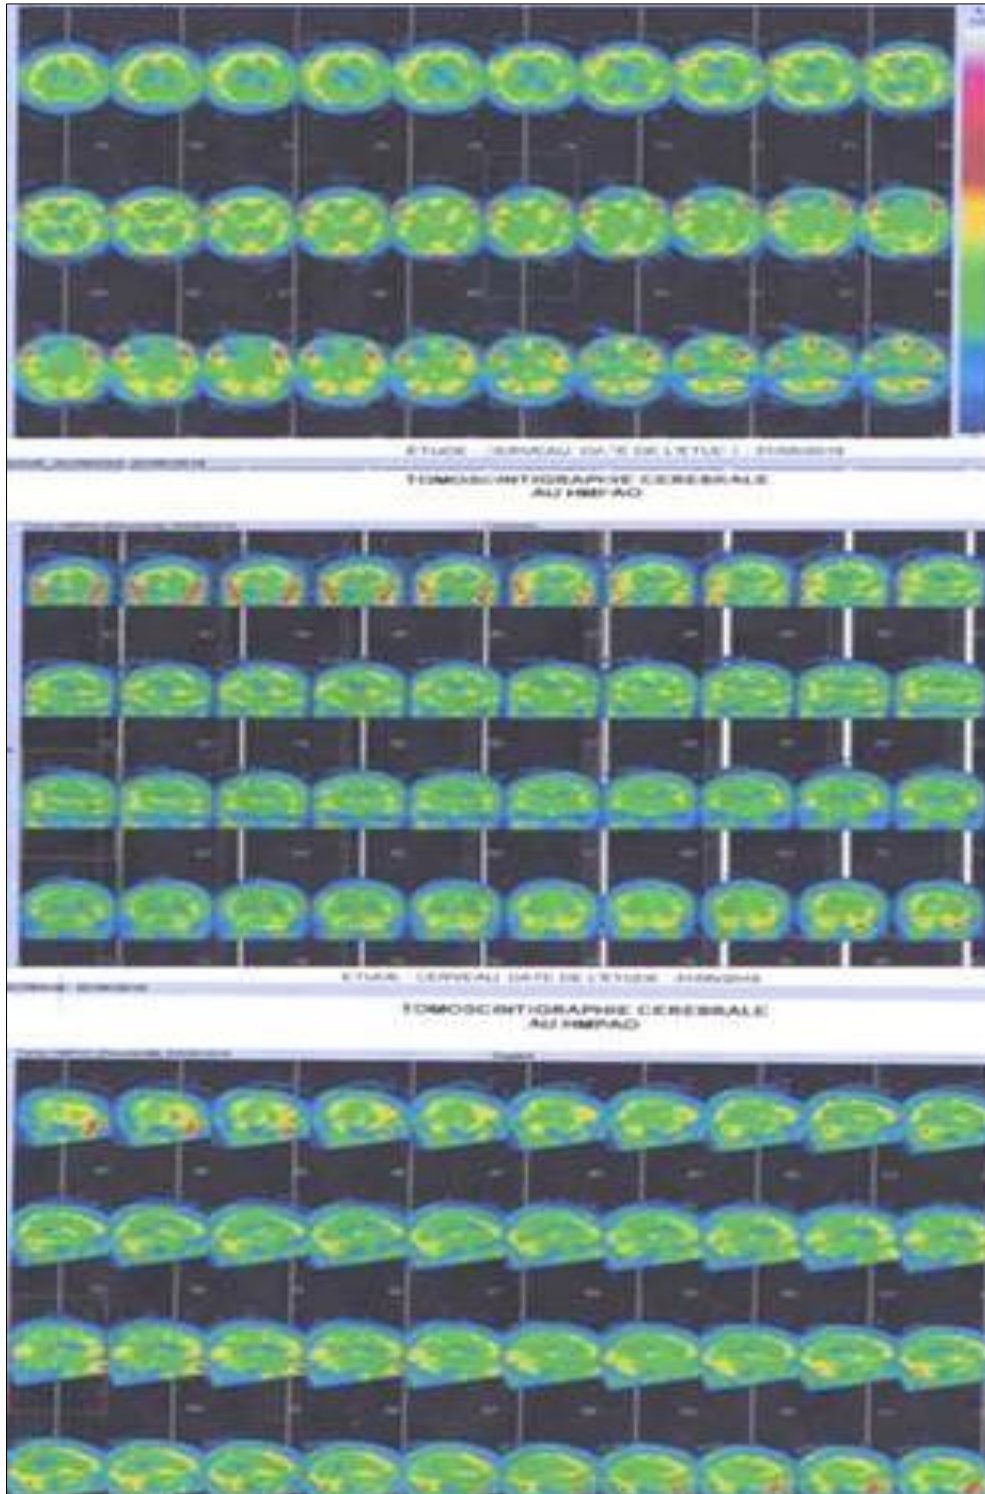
Interictal cerebral SPECT/CT (sections: axial, transverse and sagittal)
